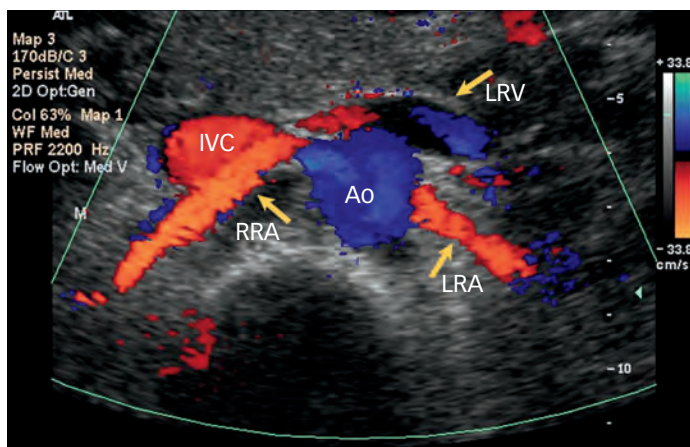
Transverse image of the abdominal aorta (Ao), showing the following vessels with an accompanying arrow: right (RRA) and left (LRA) renal arteries and left renal vein (LRV), which can be insonated with an appropriate Doppler angle. Note also the inferior vena cava (IVC), to the left of the aorta and the left renal vein. Courtesy of UC Davis Medical Center.
